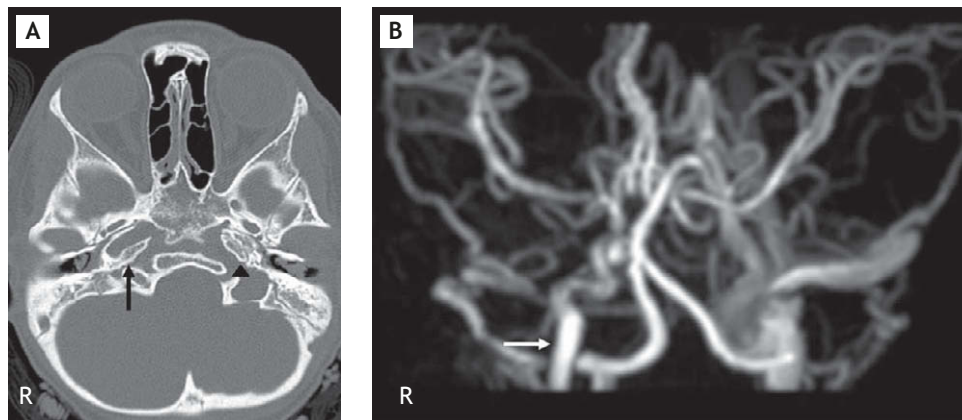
(A) Computed tomography of the skull base showing the absence of the carotid canal on the left (arrowhead) and a normal-sized canal on the right (arrow). (B) Magnetic resonance angiography of the brain showing agenesis of the left internal carotid artery and preservation of the right internal carotid artery (arrow). R=right side.
